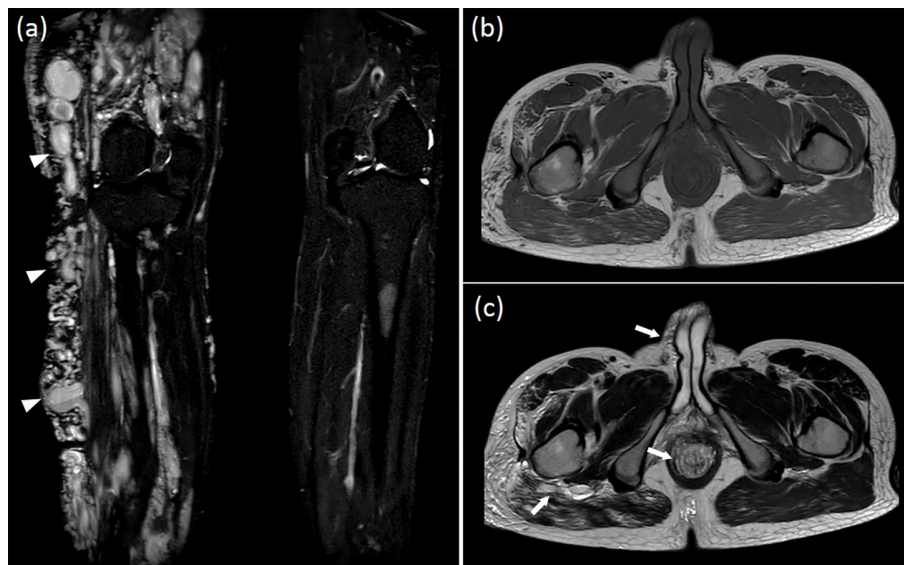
The magnetic resonance imaging. (a) A coronal view showed superficial and deep venous dilatation along the lateral side of the right thigh and leg (arrowheads) (STIR sequence). (b, c) An axial view showed dilated vascular vessels in the lateral aspect of the right pelvic and scrotal sac with varices in the rectum (arrow). (b, T1W–TSE image; c, T2W–TSE image)
